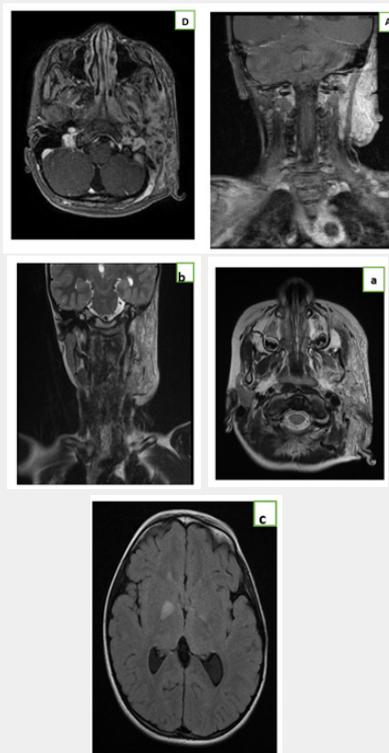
IRM cerebral T2 axial and coronal cut (a and b), axial FLAIR (c); showing a voluminous mass latero-left cervical infiltrates the homolateral hemiface and extends to the deep spaces of the face in relation to a neurofibroma associated with abnormalities of the white substance in relation to OBNI.
